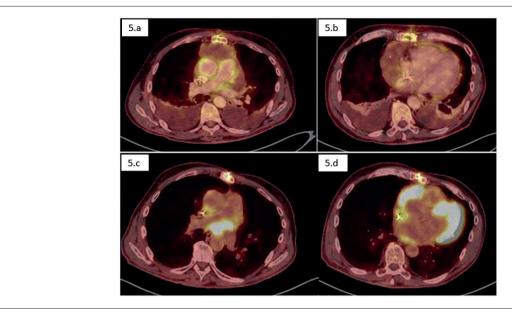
Axial PET-SCAN images using the radiopharmaceutical FDG that represent respectively: 5. a and 5.b) absence of anomalous uptake on June 8, 2023. 5.c and 5.d) anomalous uptake of the radiopharmaceutical showing a hypermetabolic expansive lesion in the right atrial surgical bed, in close contact with its lateral and posterior wall and without well-defined cleavage planes. Also, there was a radiopharmaceutical concentration in the topography of the cardiac base on January 3, 2024.
